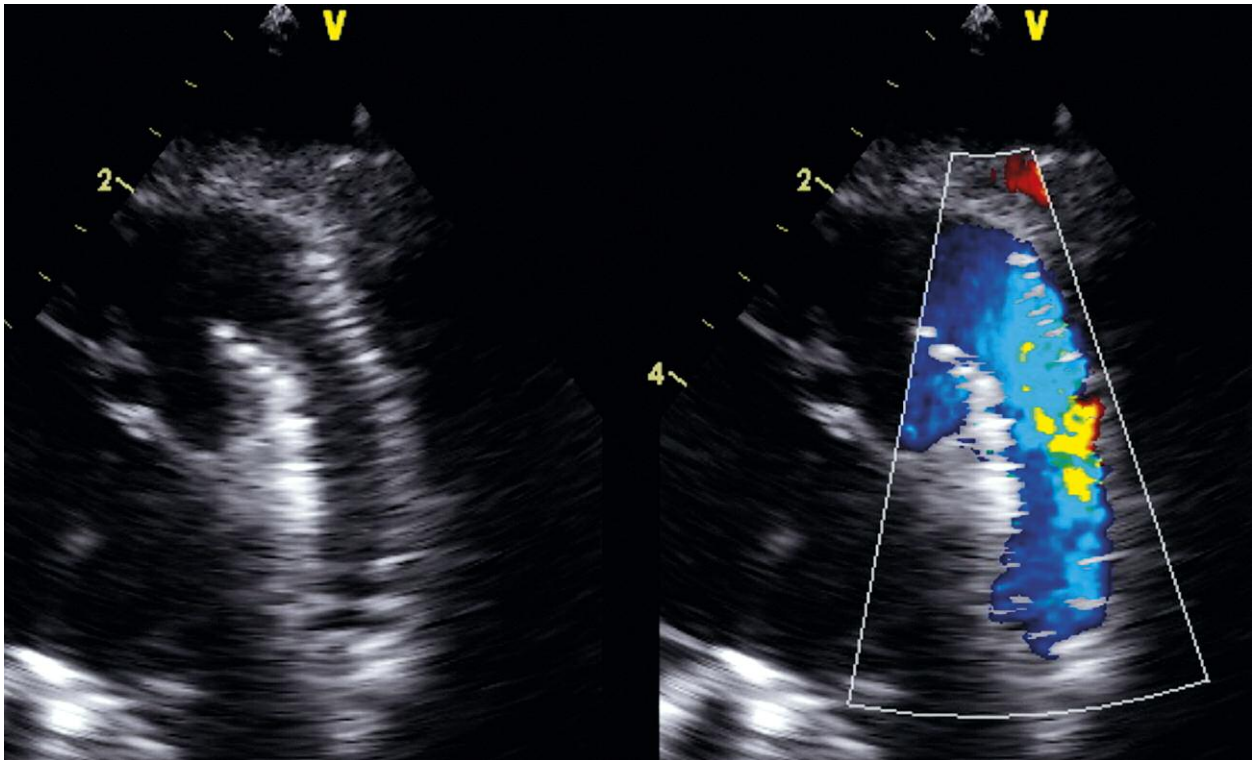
Control echocardiographic examination after second stent into ductus arteriosus implantation – non-restrictive blood flow from pulmonary artery into aorta
